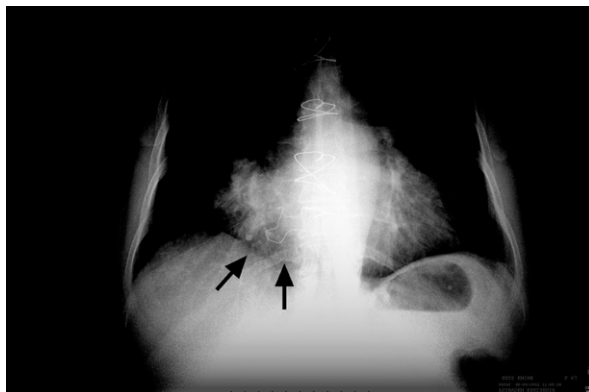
Patient 1. Radiograph shows a mass adjacent to the right atrium, with a whorl-like radiopaque marker.
